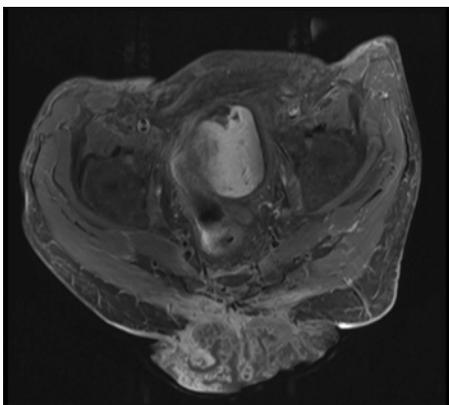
MRI showing the extent of the sinus reaching the gluteal muscle.
